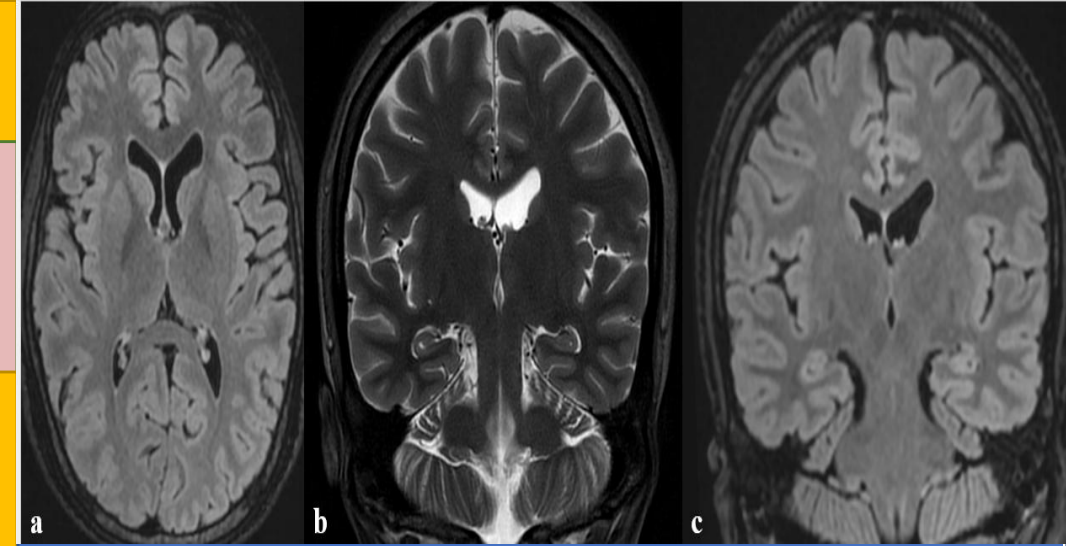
The axial FLAIR MRI (a), oblique coronal T2 (b), and FLAIR (c) did not show any obvious abnormality to explain seizures. No acute seizure-related changes were demonstrated
